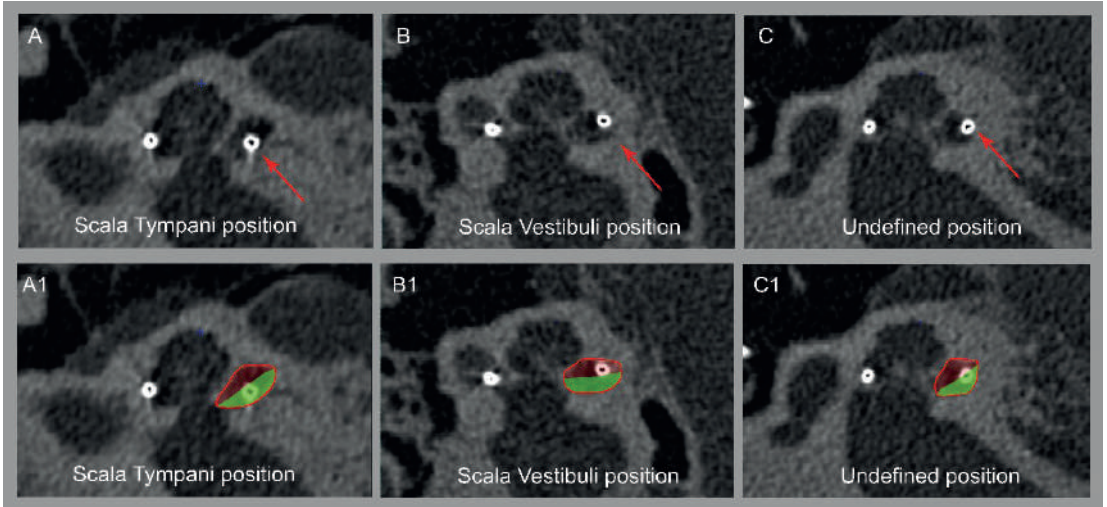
Method for measuring scalar location using mid-modiolar sections of an ultra-high-resolution computed tomography (UHR-CT) scan. Examples of electrode contacts in different scalar positions: In the panels A1, B1, and C1, the scala tympani (ST) is roughly denoted by the green area, and the scala vestibuli (SV) is roughly indicated as the red area. The scala media is not visible. Dependent of the location of the electrode contact, the position was defined as contact in ST position (A and A1), SV position (B and B1), or undefined (C and C1). An undefined position, defined as a contact located between the two scalas, was only found if the electrode translocated from one scala to the other. The independent variable scalar trajectory was categorically defined as (1) all contacts in ST, (2) all contacts in SV, or (3) translocation between ST and SV.
